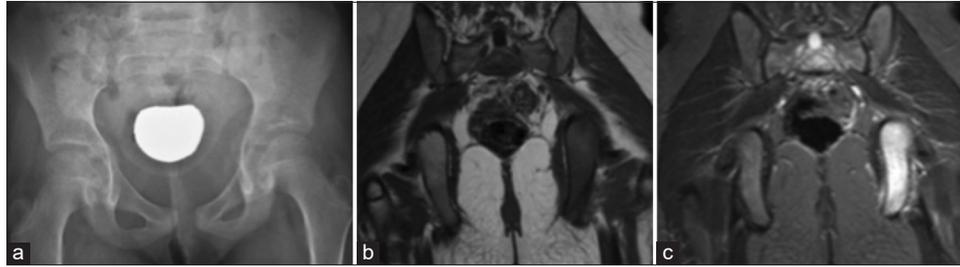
Tuberculosis, radiograph (a), coronal T1 (b), and short-tau inversion recovery (c) demonstrating edema in the left ischium which on biopsy proved to be tuberculosis.
